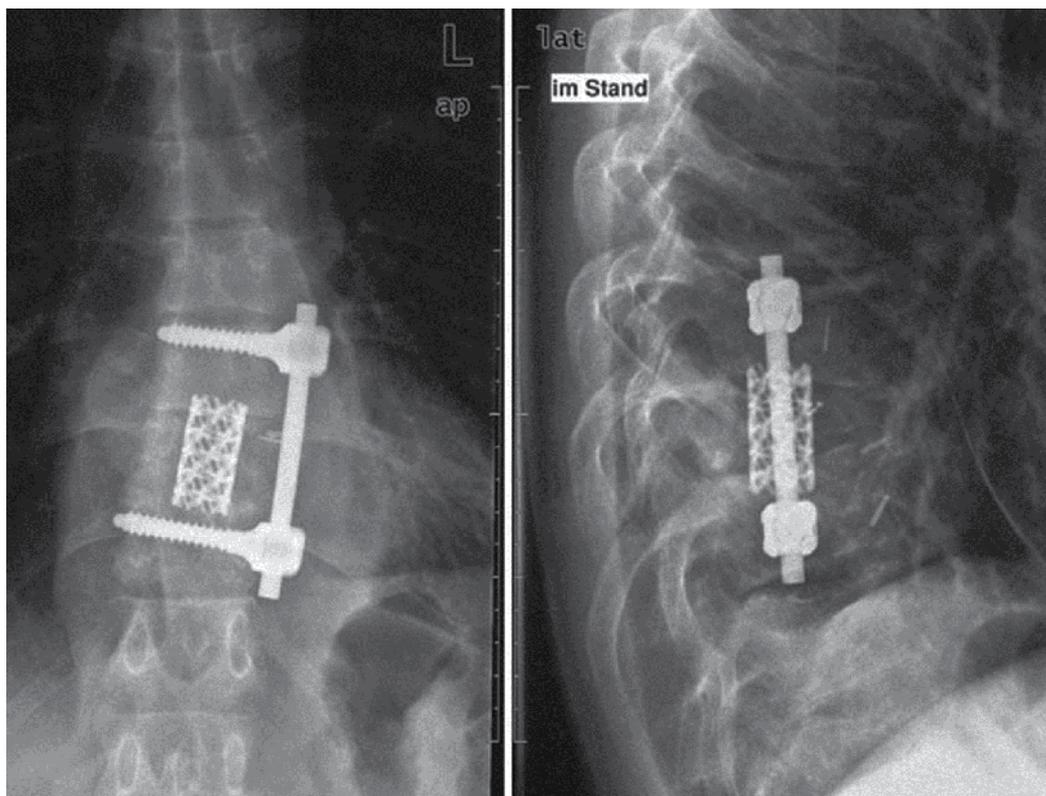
Spondylodiscitis (*Mycobacterium Xenopi*). Control X-ray after debridement of the infected segment and ventral spondylodesis. It shows a properly inserted cage (titanium, Pyramesh, Medtronic) and an anterolateral monobar system (titanium, ART system, AMT).
